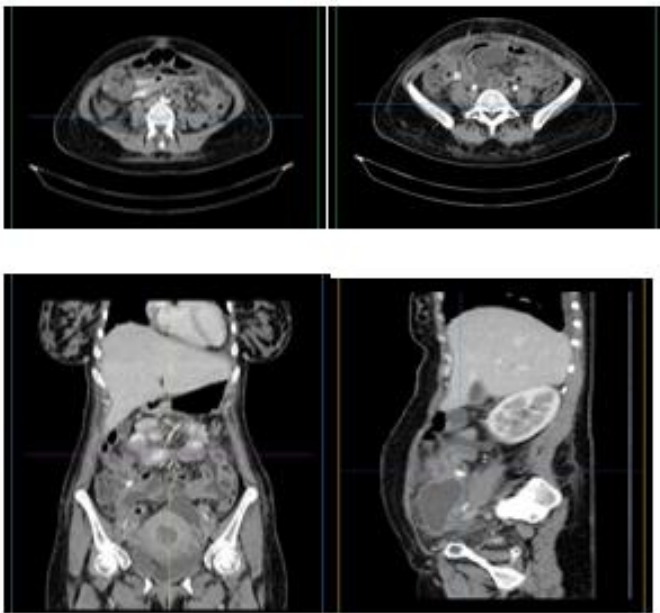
Contrast CT scan (Abdomen+Pelvis)
